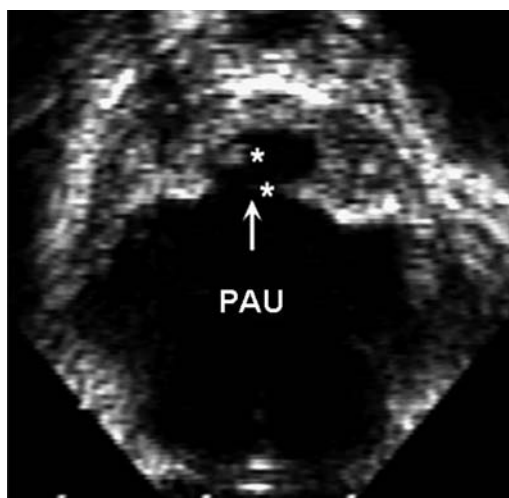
Transesophageal echo (TEE) cross sectional image of descending thoracic aorta demonstrating a penetrating aortic ulcer (arrow) and the asterisks point to the overlying mobile debris.
